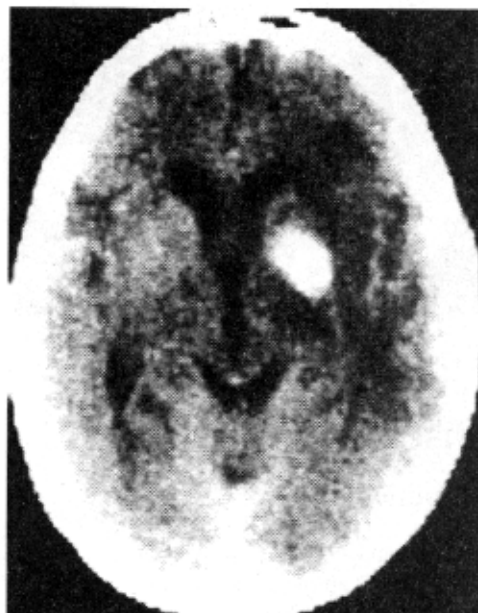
Contrast CT scan brain showing hyperdense tumor with little mass effect.
